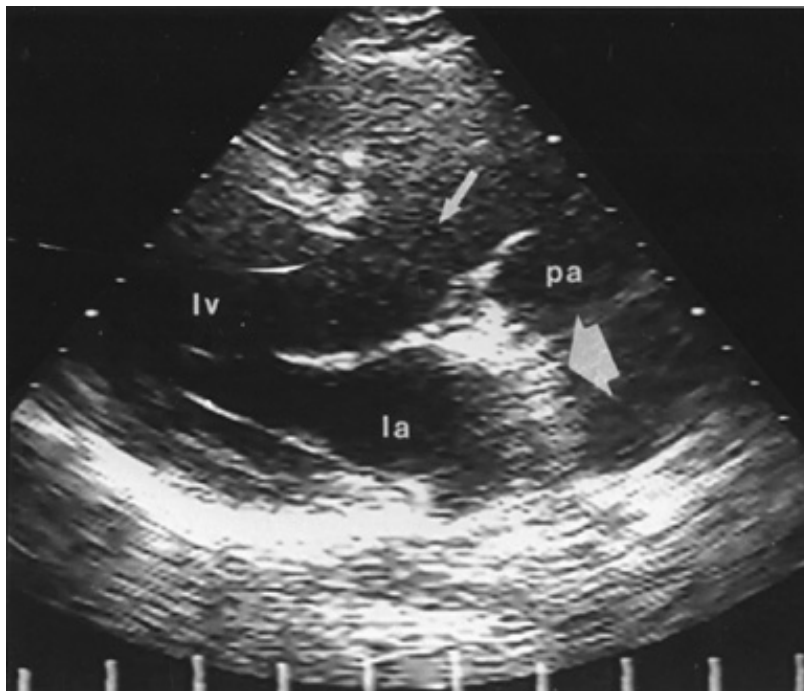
Parasternal long-axis image of double-outlet right ventricle. A large VSD is present (*small arrow*) and the normal continuity between the posterior aortic wall and the anterior mitral leaflet is absent. Fibrous tissue is seen (*large arrow*) between the left atrium (LA) and the nearest great vessel (in this case, the pulmonary artery (PA)). LV = left ventricle.
